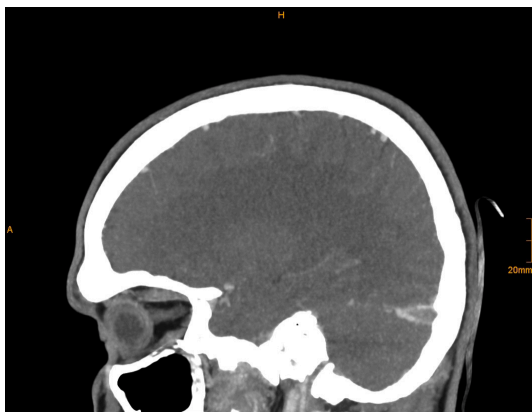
CT venogram showing significant cerebral venous sinus thrombosis.
